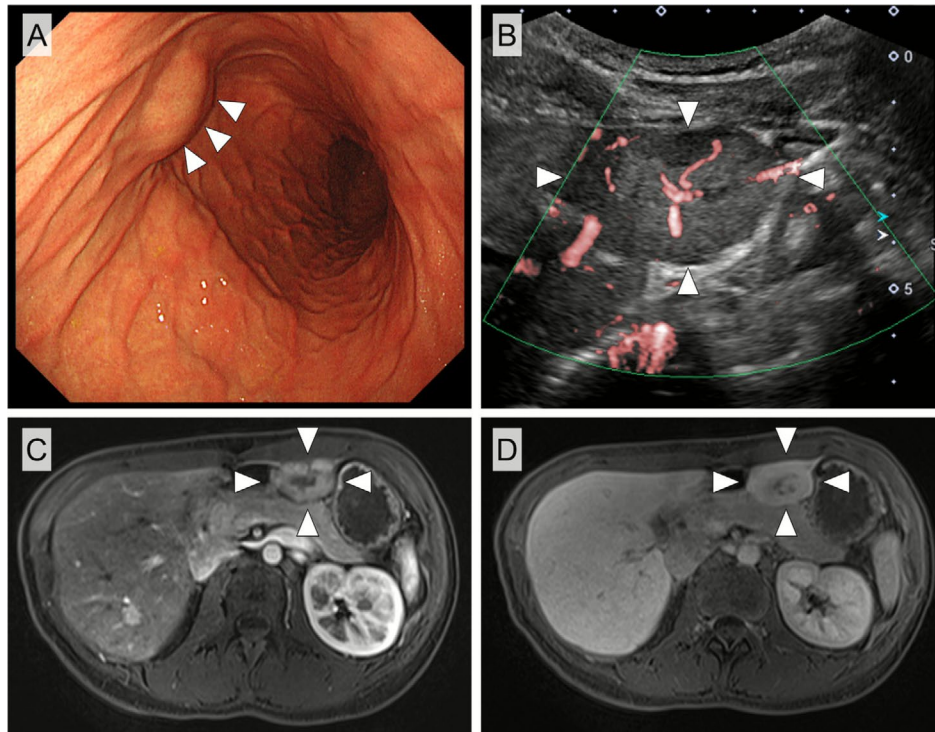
(A) Esophagogastroduodenoscopy showed a smooth, submucosal bulge in the mid-gastric body. (B) Abdominal ultrasound identified a central scar with a spoke-wheel pattern. Gadoxetic acid-enhanced magnetic resonance imaging of the abdomen demonstrated a well-circumscribed hepatic lesion in the left lobe causing extragastric compression, with homogeneous arterial-phase hyperenhancement (C) and subsequent isoenhancement in the delayed phase (D).
